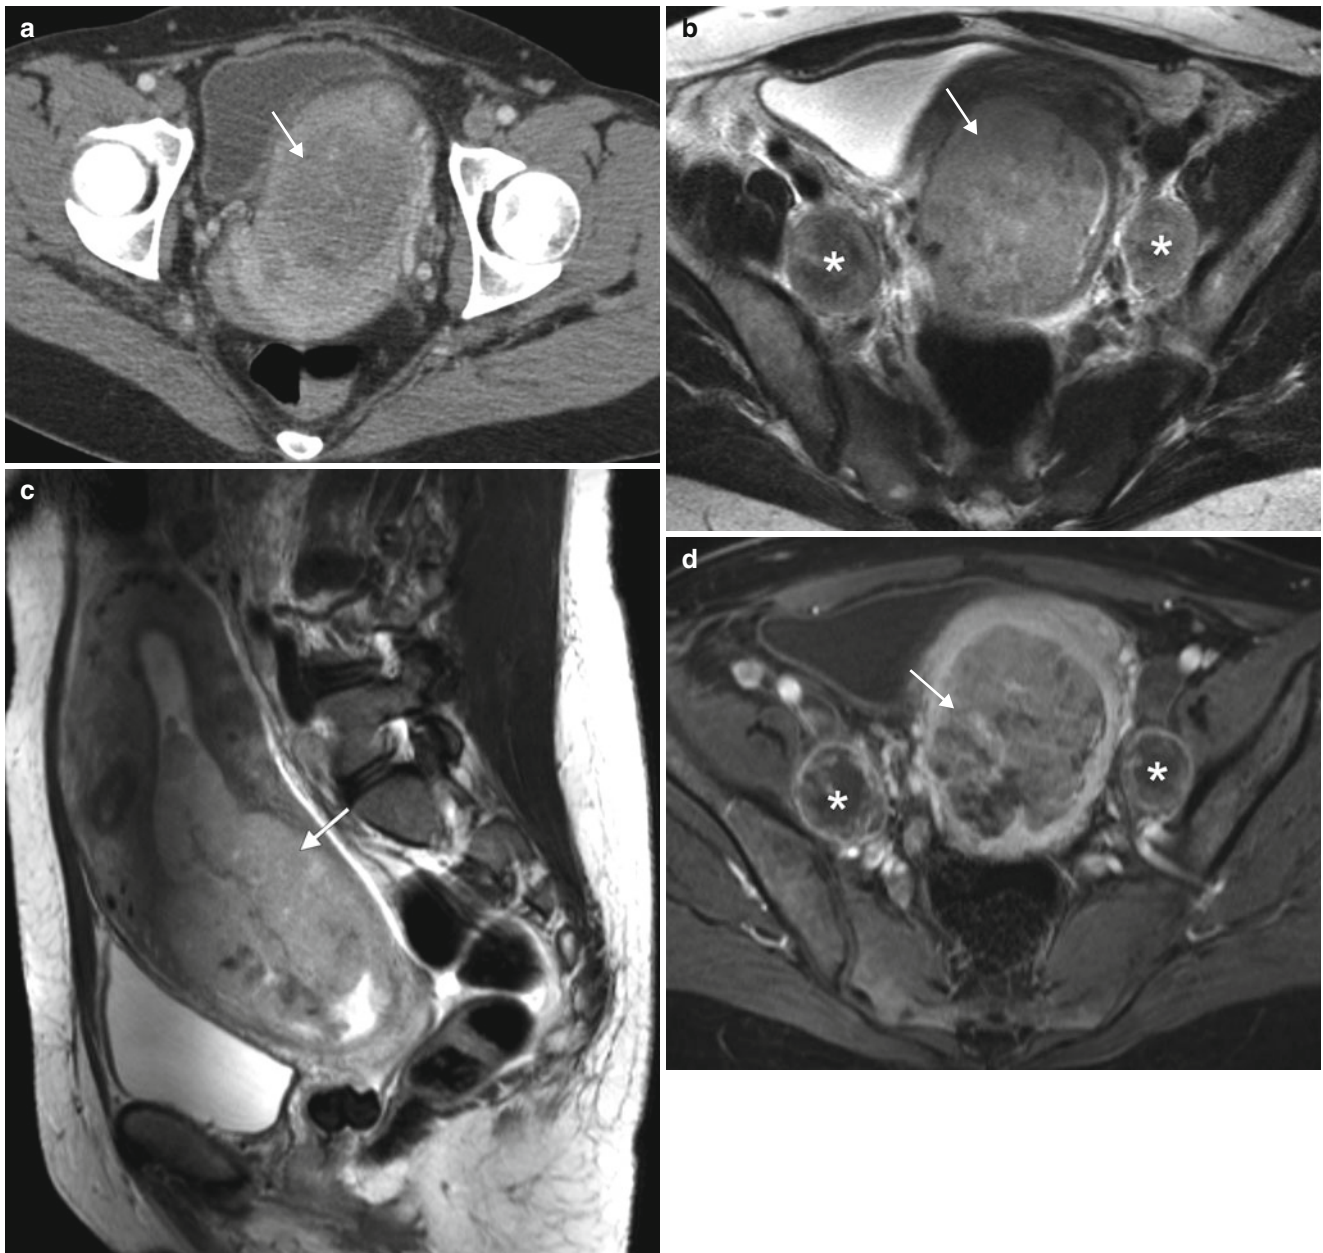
51-year-old woman presenting with vaginal discharge and crampy abdominal pain. An axial, contrast-enhanced CT scan (a) demonstrated a heterogeneously enhancing uterine mass. Axial (b) and sagittal (c) T2-weighted MR images and fat-suppressed axial (d) and sagittal (e) T1-weighted images following intravenous gadolinium
